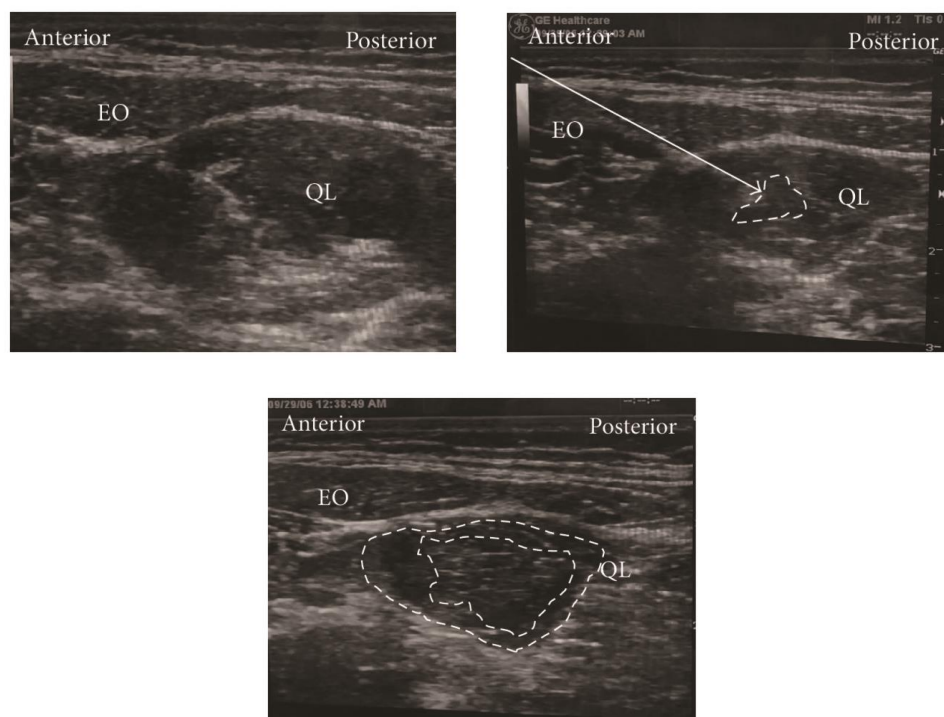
Ultrasound images of intramuscular QLB. (a) Preinjection, (b) test injection, and (c) postinjection. EO: external oblique muscle, QL: quadratus lumborum, white arrow: needle trajectory, and white dotted line: spread of local anaesthetic within (b) or in between (c).
